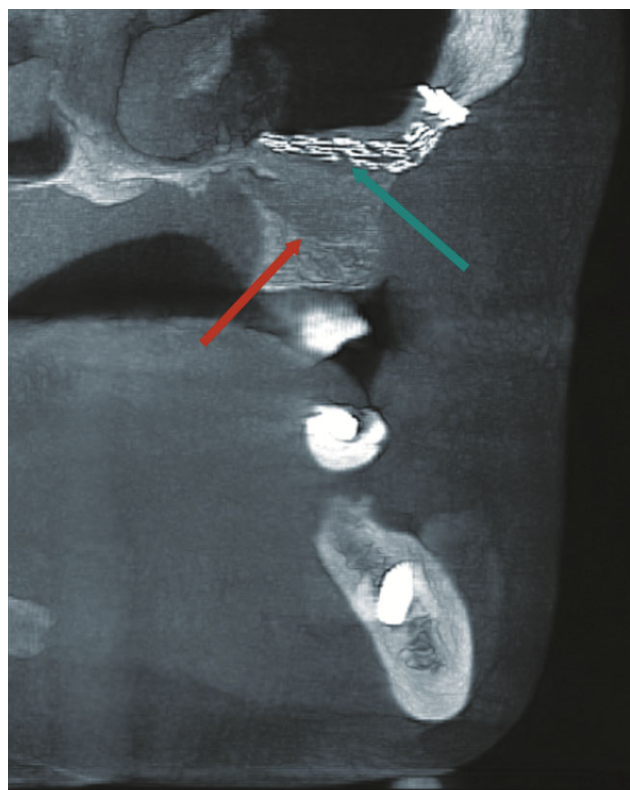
Reformatted cross-sectional view from the 6 months postoperative CBCT showing incomplete bone filling under the mesh (green arrow), and a line of demarcation between the native and the newly formed bone (red arrow).
